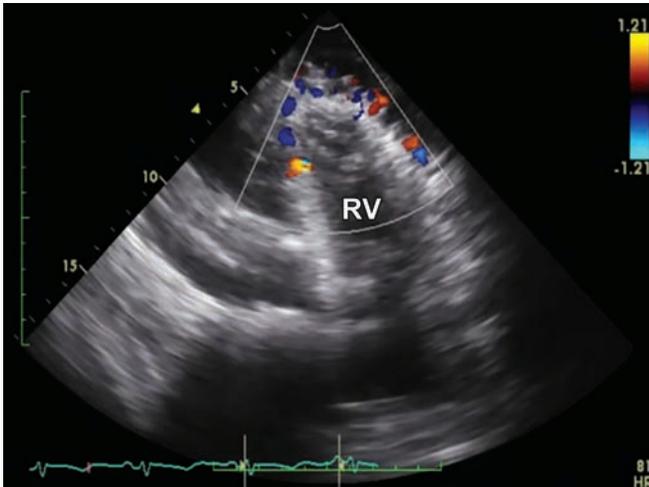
2D echocardiogram—Right ventricular inflow view demonstrating multiple abnormal color flow Doppler signals around the right ventricular free wall and apex exhibiting the typical "Christmas tree" pattern described with ARCAPA. Right ventricle (RV).
